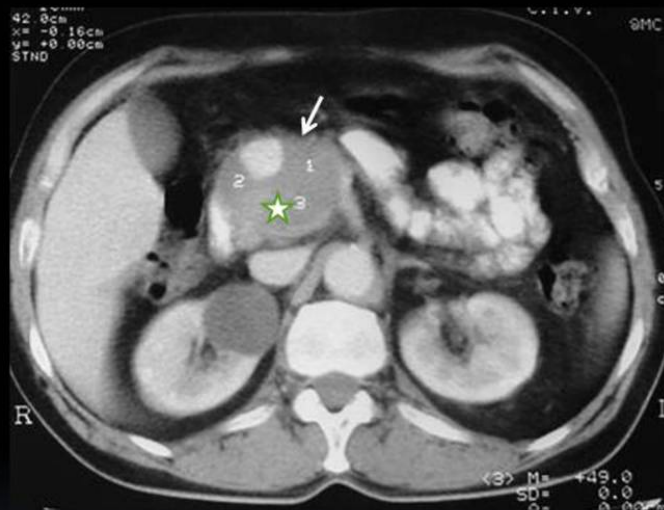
CT scan demonstrates a false aneurysm of the gastroduodenal artery (*arrow*) with extensive thrombosis (*asterisk*).
